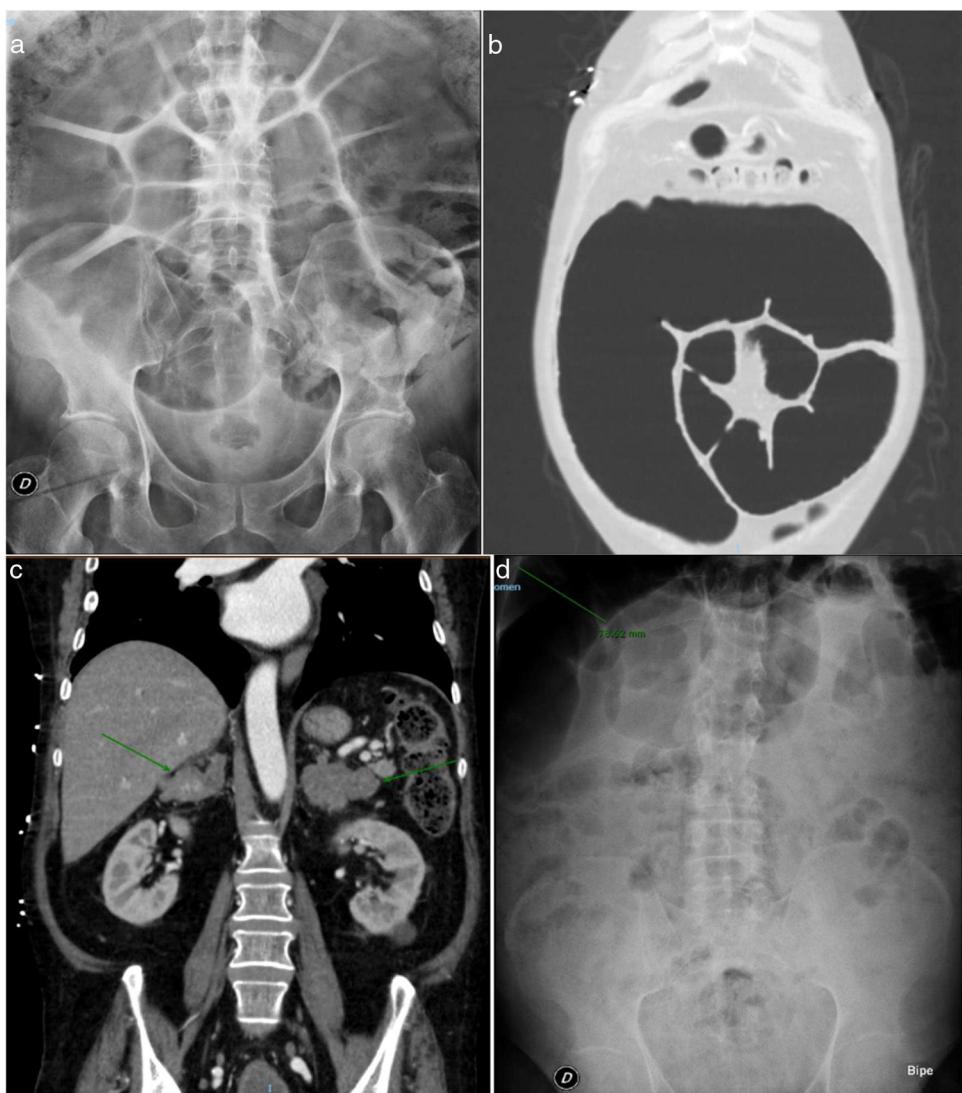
a) Plain abdominal X-ray view. Large left colon distension with a maximum diameter of 11.2 cm. b) CAT scan of the chest and abdomen. Large sigmoid colon dilatation. c) CAT scan of the chest and abdomen. Greatly enlarged adrenal glands of hyperplastic appearance. d) Plain abdominal X-ray view. Colon calibre reduction to 7.8 cm following bilateral adrenalectomy.
